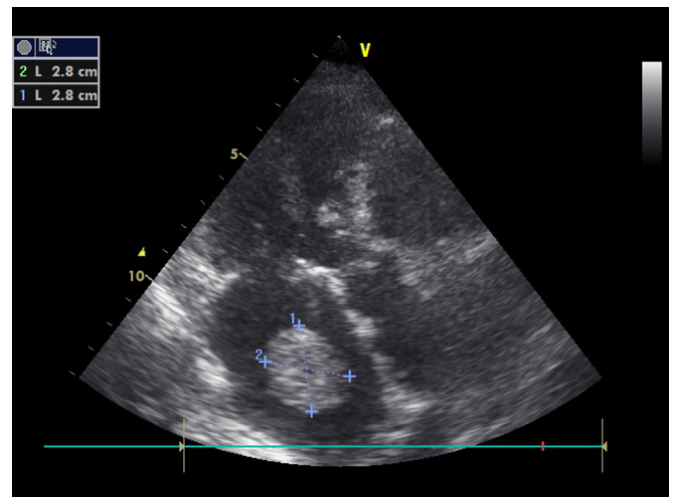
Transthoracic echocardiography showing a large free-floating mass in the left atrium.
